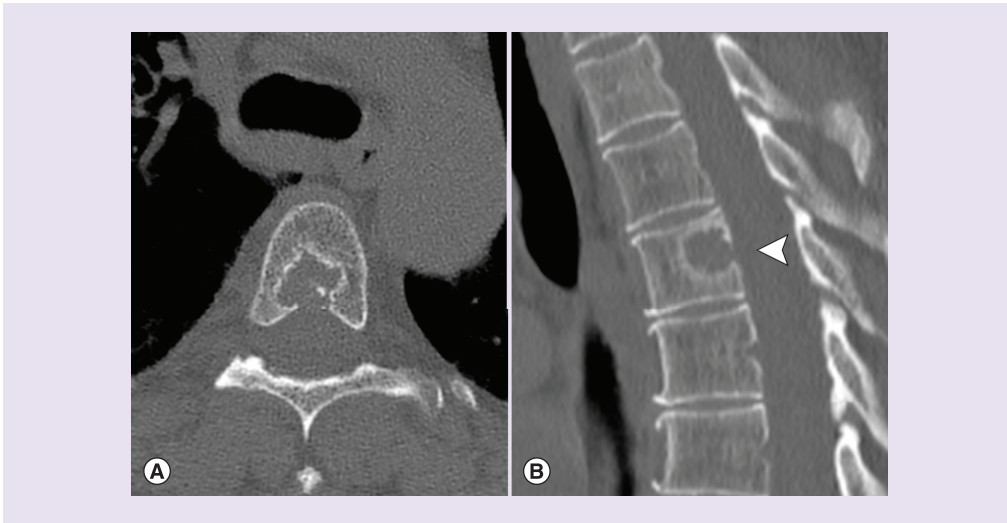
Progressing lesion in vertebra T5 after 20 months of lenvatinib treatment. CT scan of the progressing lesion in vertebra T5 from (A) axial and (B) sagittal view.
